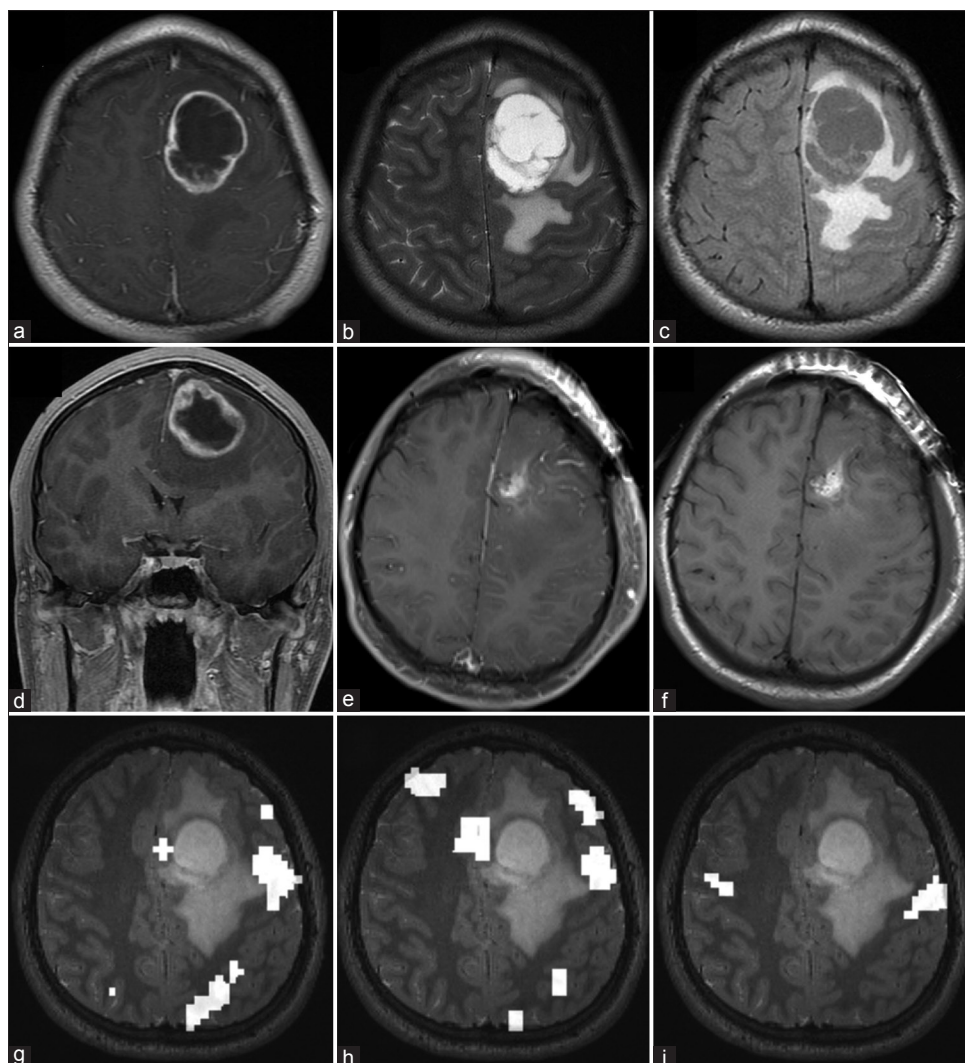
Preoperative and postoperative MRI of RELA-fusion positive ependymoma. Preoperative axial (a) T1-weighted gadolinium-enhanced, (b) T2-weighted, (c) FLAIR, and (d) coronal T1-weighted contrast-enhanced imaging demonstrate a ring-enhancing lesion with cystic central component and perilesional edema in the left frontal cortex. Postoperative (e) T1-weighted contrast-enhanced and (f) T1-weighted nonenhanced imaging show a gross total resection. Functional MRI data for (g) reading, (h) word recognition, and (i) lip movement are shown. Compared with the tumor, language cortex localizes posterolateral while motor cortex is further posterior
